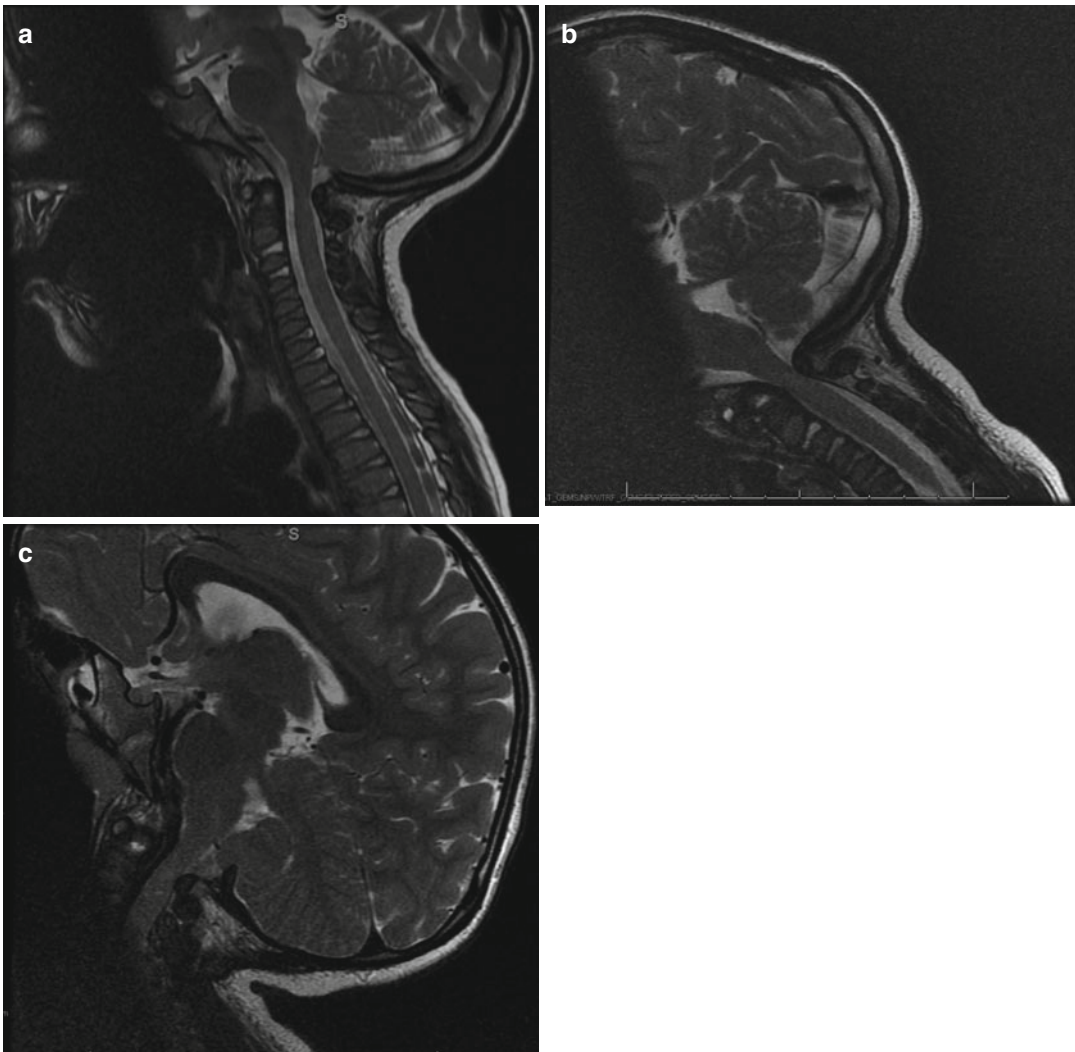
Dynamic MRI. Space available for cord (SAC) in neutral position of the MRI (a). The stenosis is most severe in flexion view (b) and improved with extension (c)
